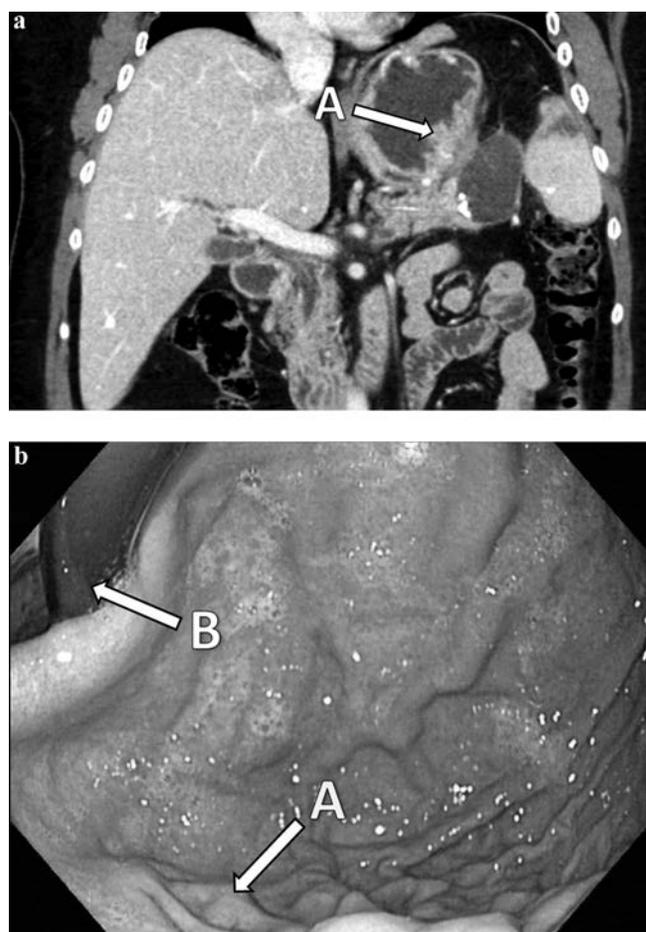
a, Abdominal CT scan after splenic artery embolization. (A, no gastric varices.) b, Gastroscopy after splenic artery embolization. (A, no gastric fundal varices; B, endoscope at cardia.)
